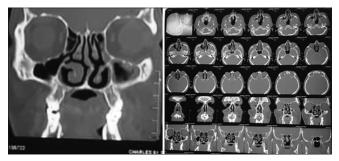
CT image of axial sectional view showing hyperdense mucosal thickening of left maxillary sinus
